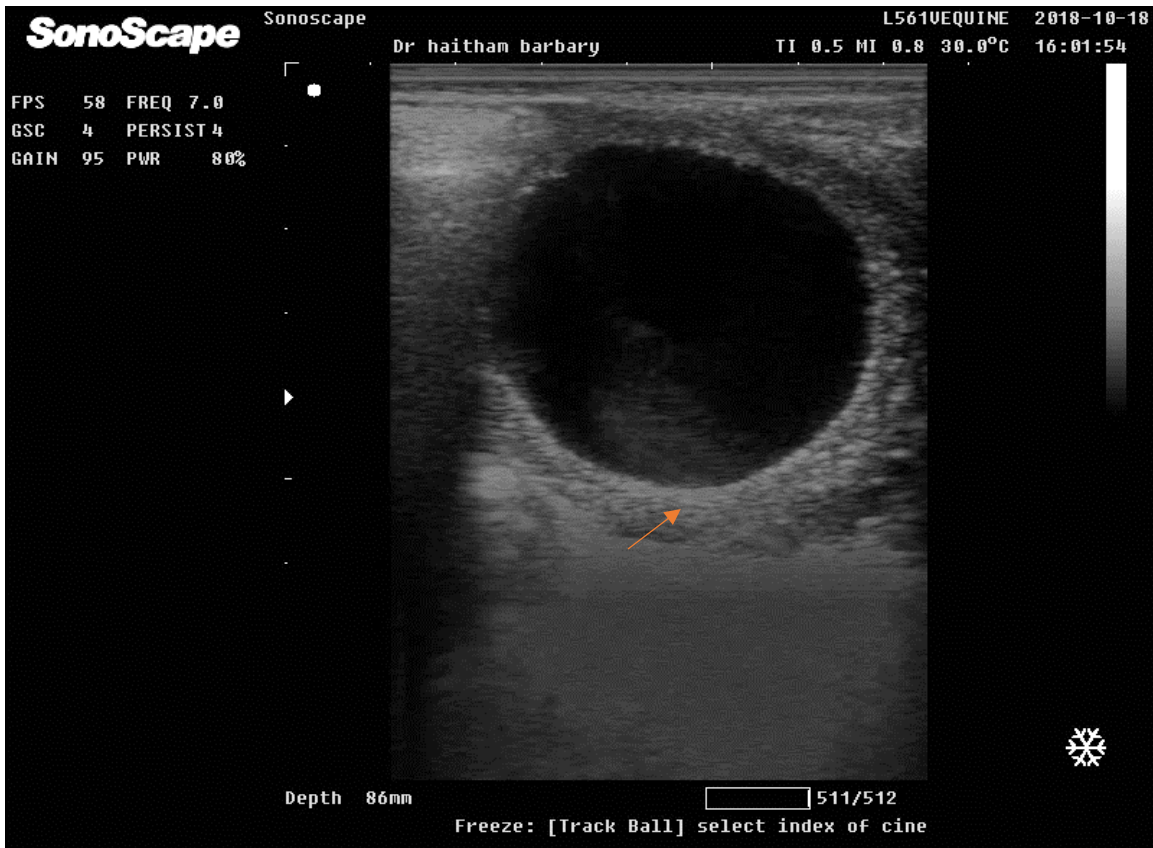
Ultrasonographic image of ovulatory follicle showed a hyperechoic thick wall (arrow)
